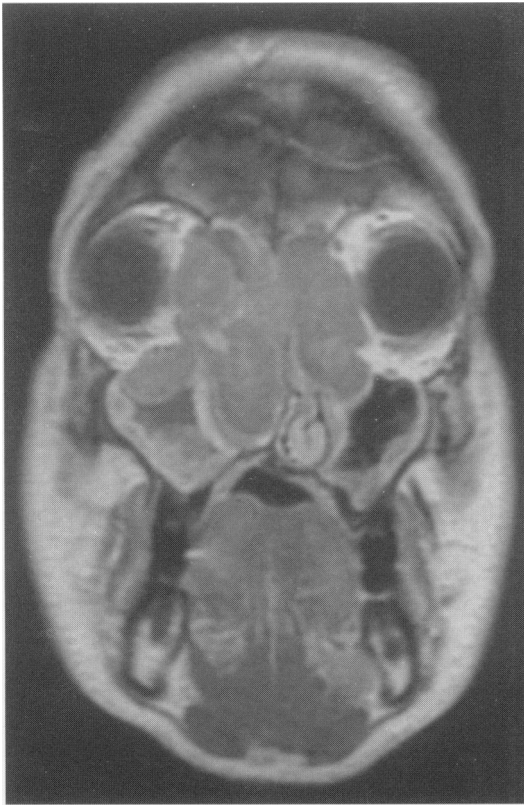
Bulky presentation of high-grade tumour outlined on magnetic resonance imaging
